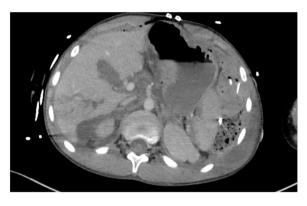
CT images showing liver lacerations and extensive irregular renal contusions.
